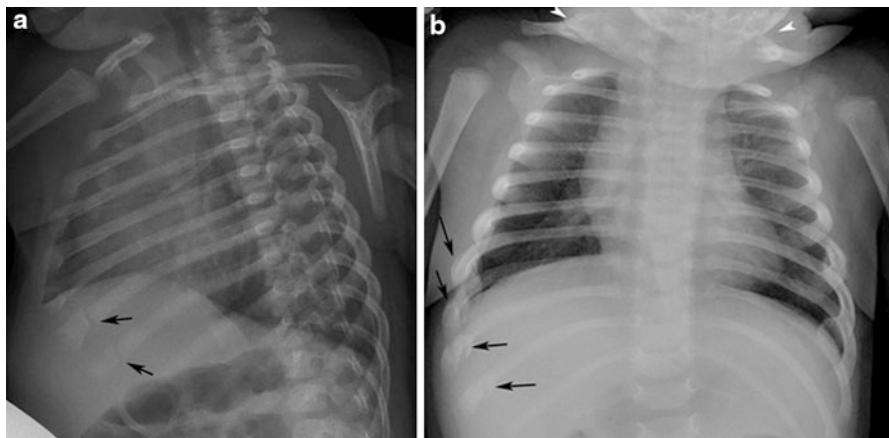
(a): Oblique chest radiograph in a 1-month-old female showing slightly displaced acute rib fractures (*arrows*) in the lateral parts of the lower right ribs. (b): Follow-up chest radiograph obtained 2 weeks from figure (a) shows callus formation at the right lower rib fracture sites (*arrows*) and in both clavicles (*arrowheads*)
